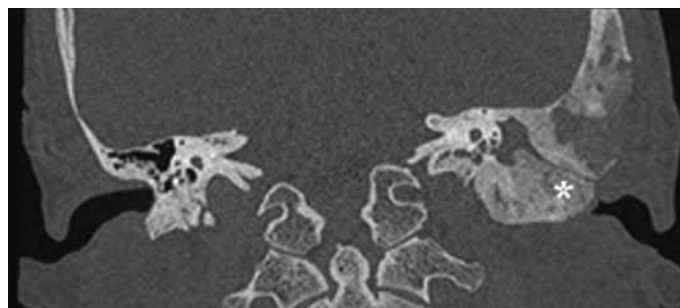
A high-resolution coronal computed tomography scan shows sclerotic and expansile fibrous dysplasia lesions invading the external auditory canal (asterisk). Complete stenosis of the ear canal is noted
